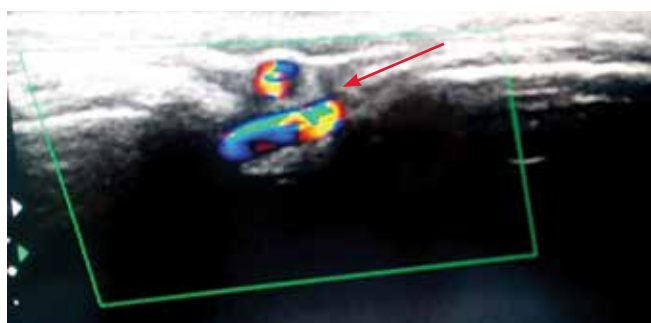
Ultrasound in the long-term postoperative period: functioning low-flow STA-MCA bypass (arrow)
